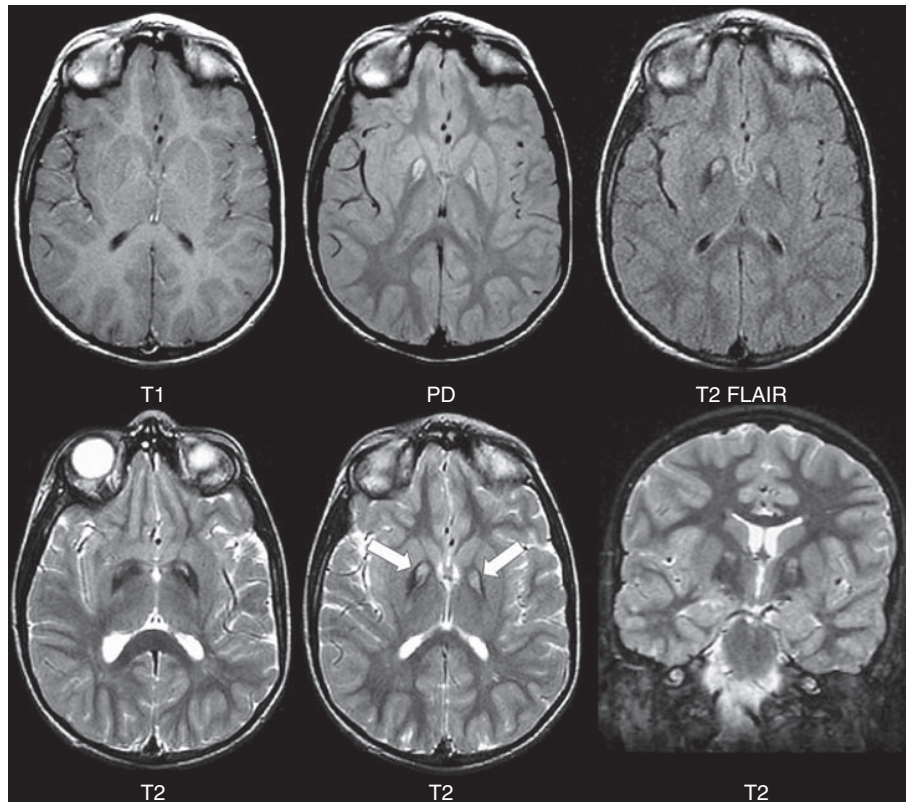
Eye-of-the-tiger sign (arrows). This *PANK2* mutation-positive child shows MR features characteristic of PKAN. The T₁-weighted images appear normal, but high signal can be seen in the globus pallidus on proton density (PD), T₂-weighted fluid attenuated inversion recovery (FLAIR), and T₂-weighted images in both the axial and coronal planes. With increasingly heavier T₂ weighting (PD < FLAIR < T₂), there is increasingly conspicuous T₂ hypointensity at the periphery due to the magnetic susceptibility effects of excess iron.
